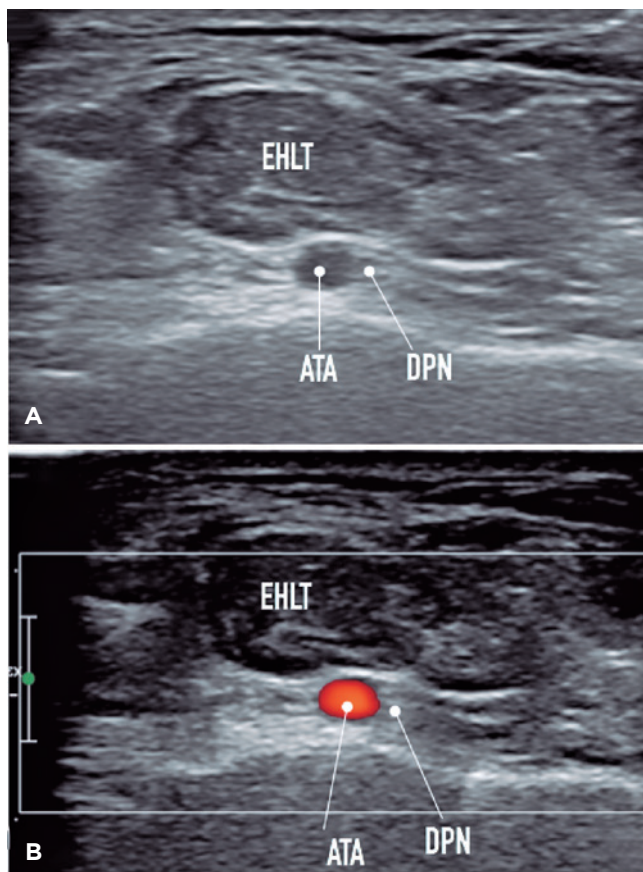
The images show the relationship of the deep peroneal nerve (DPN) with the anterior tibial artery (ATA), deep to the extensor hallucis longus tendon (EHLT). A) B-mode image with the anatomical relationship of vasculonervous structures. B) Color Doppler technique allows differentiation of the vascular structure from the adjacent nerve.
